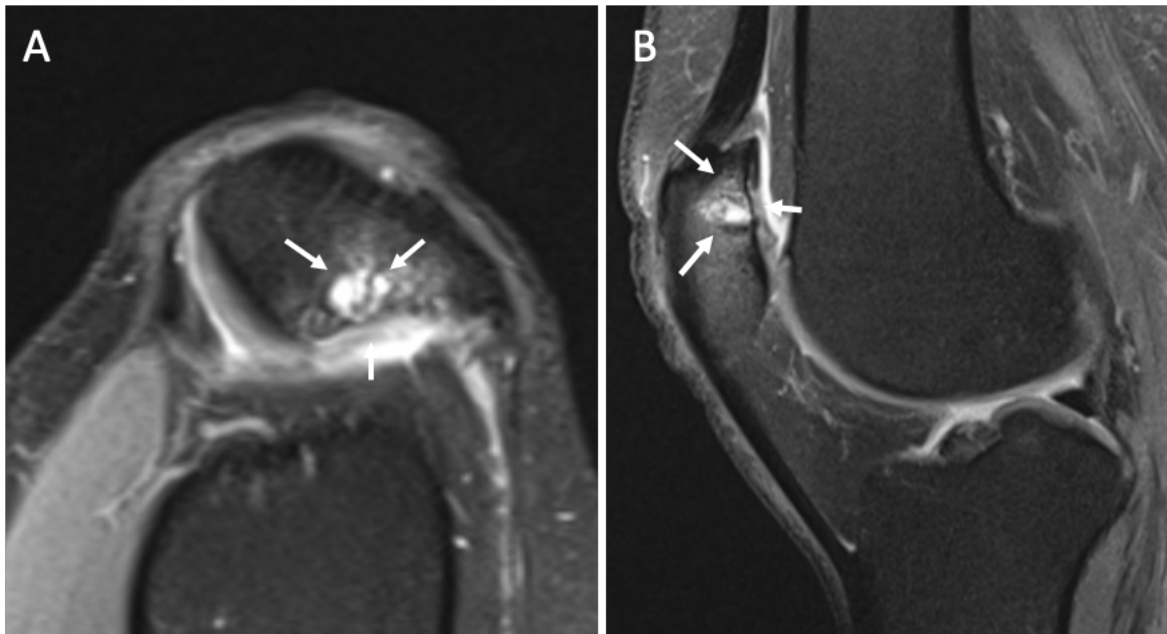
Magnetic resonance imaging (3 Tesla) of a full thickness cartilage defect with a subchondral cyst. Axial (A) and sagittal (B) fat-suppressed intermediate-weighted images demonstrating a full thickness cartilage lesion with an underlying subchondral cyst.⁵³
